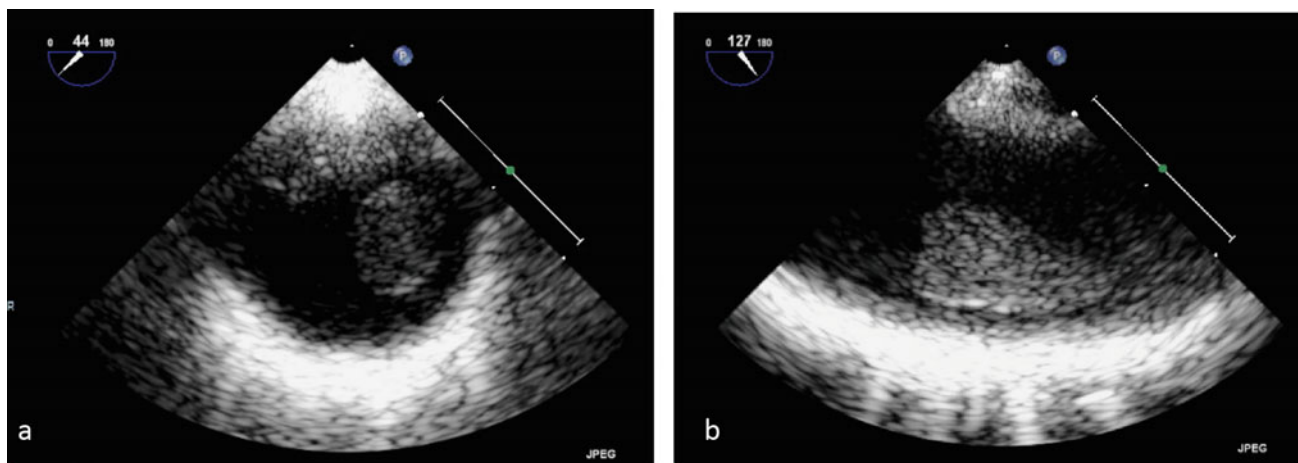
Transesophageal echocardiogram demonstrates large mobile echodensity (see Video 20.1). a short axis, b long axis
